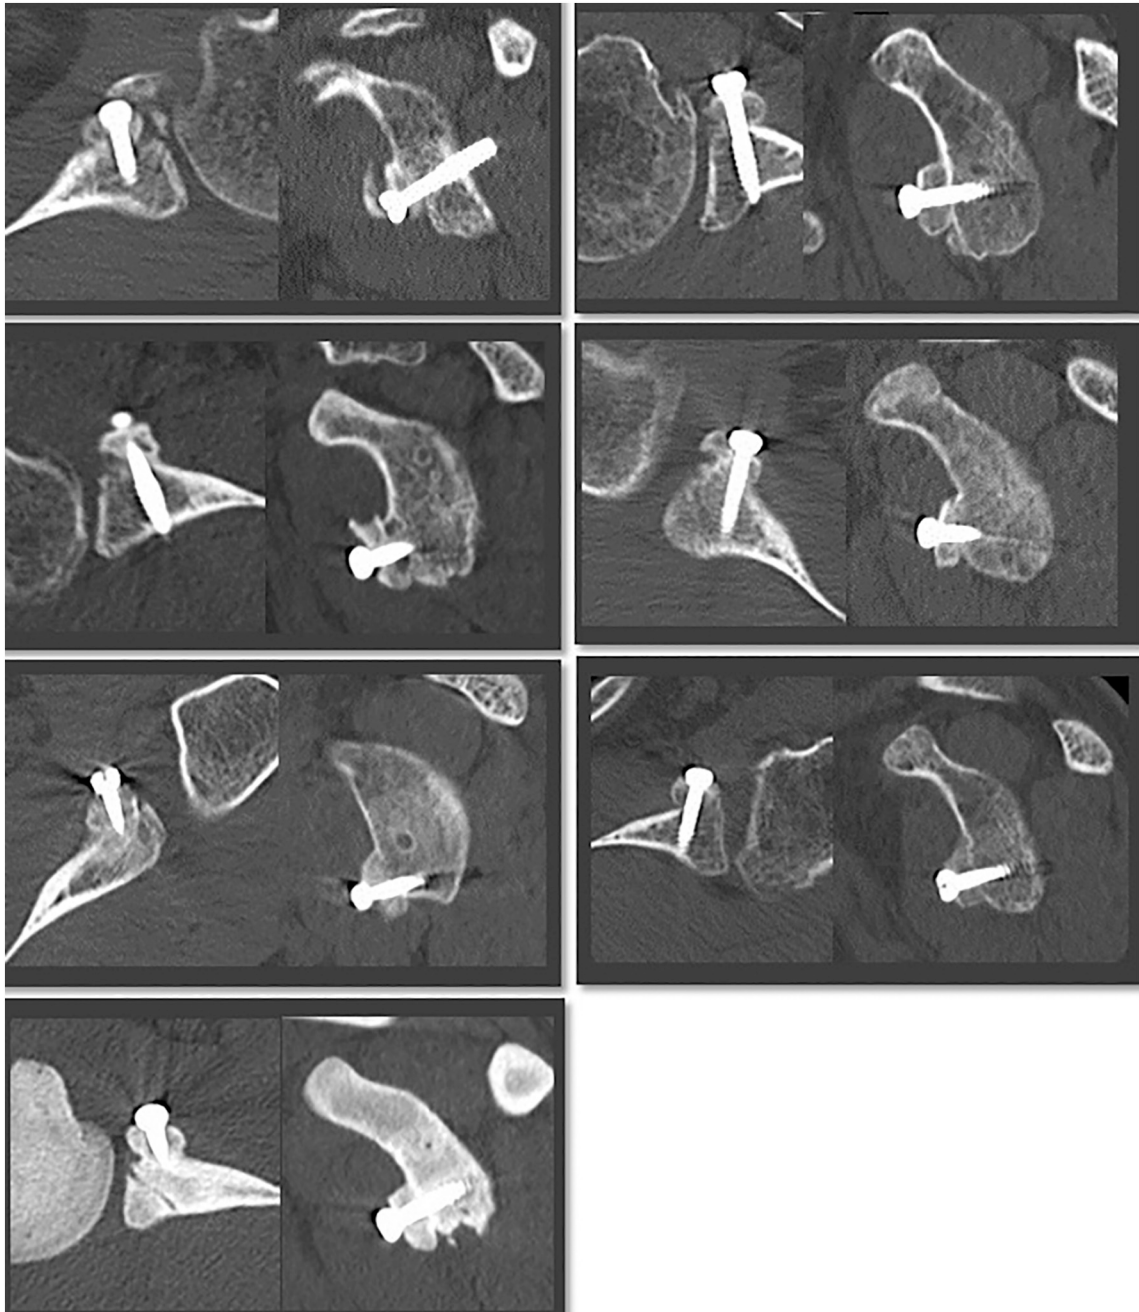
CT images at 3 months: 7 shoulders showed bone union at 3 months.
